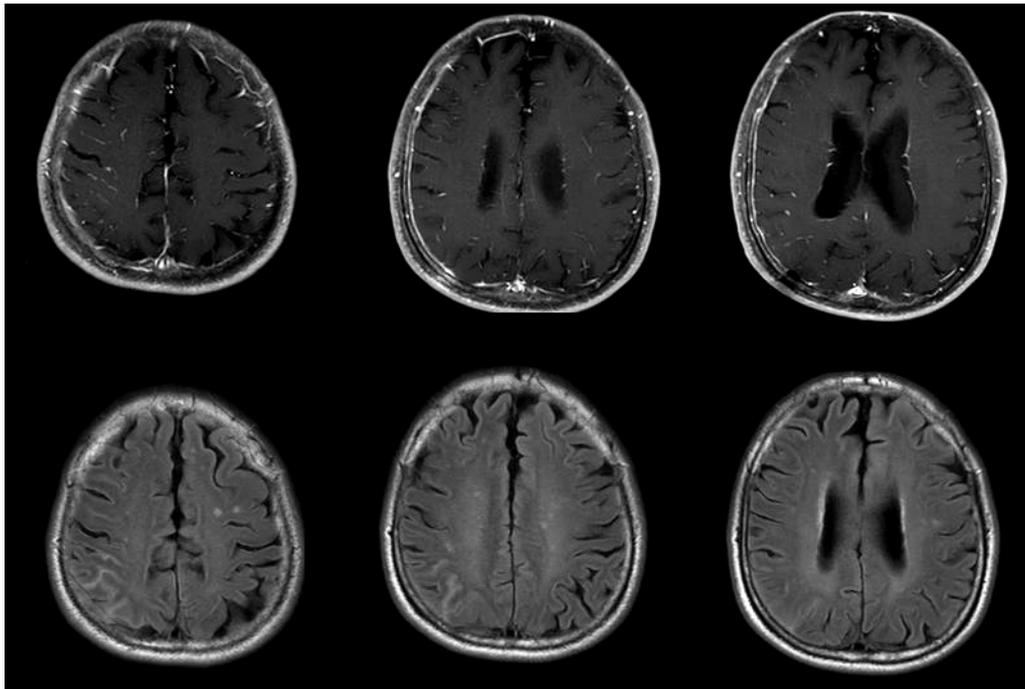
The brain MRI of the patient. The pachymeningeal enhancement on the right fronto-temporo-parietal area (upper panel: gadolinium enhanced T1-weighted image) was evident and the abnormal high signal intensity was seen along the right parietal cortex (lower panel: FLAIR-weighted image).
